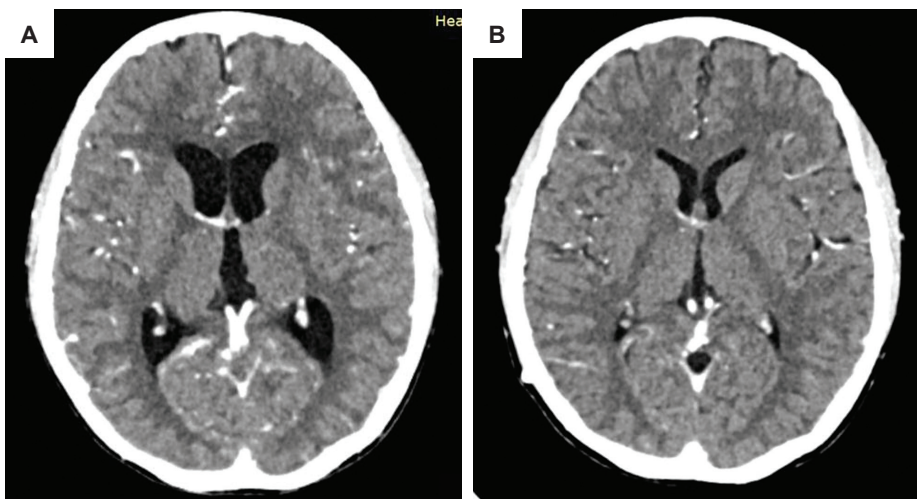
(A) Contrast CT of the brain on admission demonstrating diffused bilateral cerebellar oedema with obstructive hydrocephalus. (B) Repeat Contrast CT of the brain showed resolved cerebellar edema and obstructive hydrocephalus.
